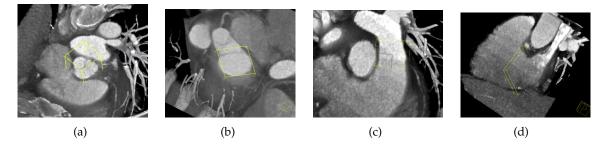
Examples of global dynamic motion estimation in cardiac CT: (a) aortic valve, (b) mitral valve, (c) pulmonary valve, (d) tricuspid valve.
